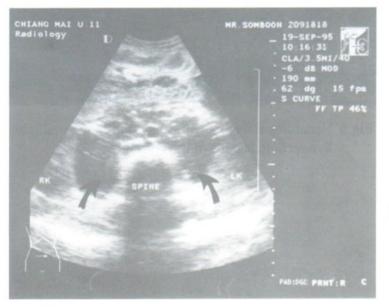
Tuberculosis. Transverse ultrasonogram shows bilateral psoas abscesses (arrows) and enlarged retroperitoneal lymph nodes (RK = right kidney, LK = left kidney).
